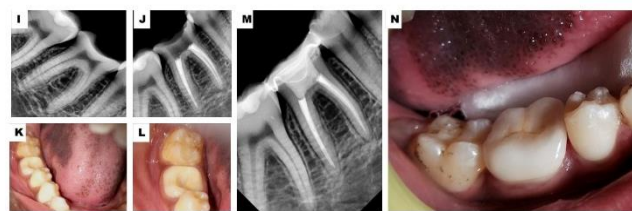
[I] PREOPERATIVE RADIOGRAPH [J] OBITUATION RADIOGRAPH [K&L] ACCESS CAVITY REFINED & ENDOCROWN PREPARATION PHOTOGRAPH [M] ENDOCROWN LUTED RADIOGRAPH [N] ENDOCROWN LUTED PHOTOGRAPH
